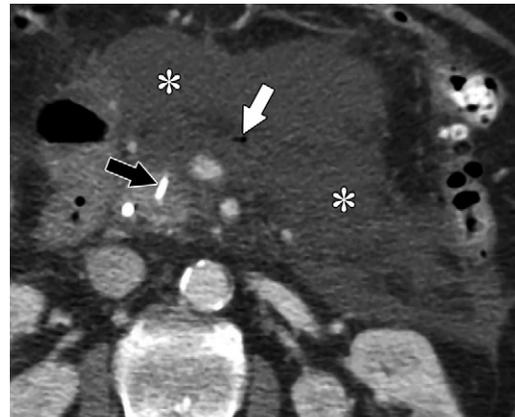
Necrotizing pancreatitis at week 3 in a 59-year-old man. Axial contrast-enhanced CT image obtained 3 weeks after disease onset shows necrosis of pancreatic neck, body, and tail (*), as well as peripancreatic necrosis. A small focus of gas (white arrow) in the pancreatic duct in the necrotic pancreatic body is secondary to recent stent placement in the duct (black arrow) and thus does not represent an infected ANC.
